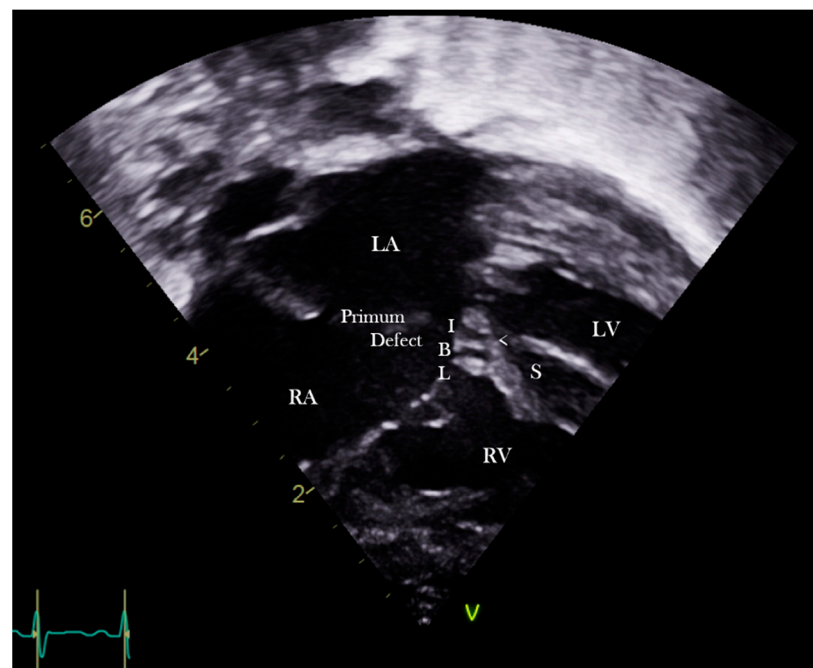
Subcostal echocardiographic four chamber section showing the inferior bridging leaflet.
